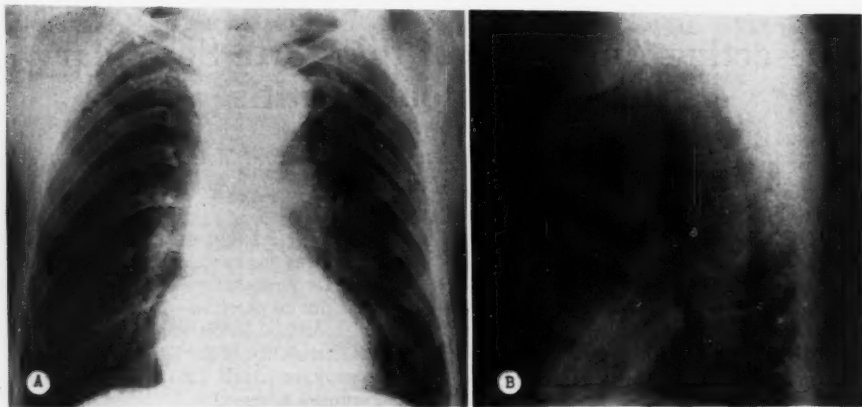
Initial roentgenogram of the chest showing cardiac enlargement, tortuous elongated aorta, and old healed calcific tuberculous in both upper lobes. A. Posteroanterior projection. B. Left lateral projection.
